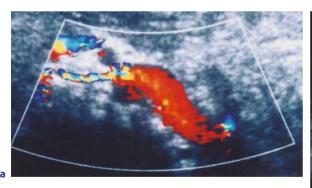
Ultrasound in pseudo-nutcracker-syndrome (= narrow crossing of left renal vein between the Aorta and the superior mesenteric artery). a Color Doppler sonography shows turbulent flow at the crossing of the left renal vein between the aorta and upper mesenteric artery. Note the marked change in diameter of the left renal vein. b Color Doppler sonography guided duplex Doppler evaluation at the side of the venous compression shows elevated flow velocity with arterialised pulsation in the left renal vein caused by propagation of aortal pulsations
